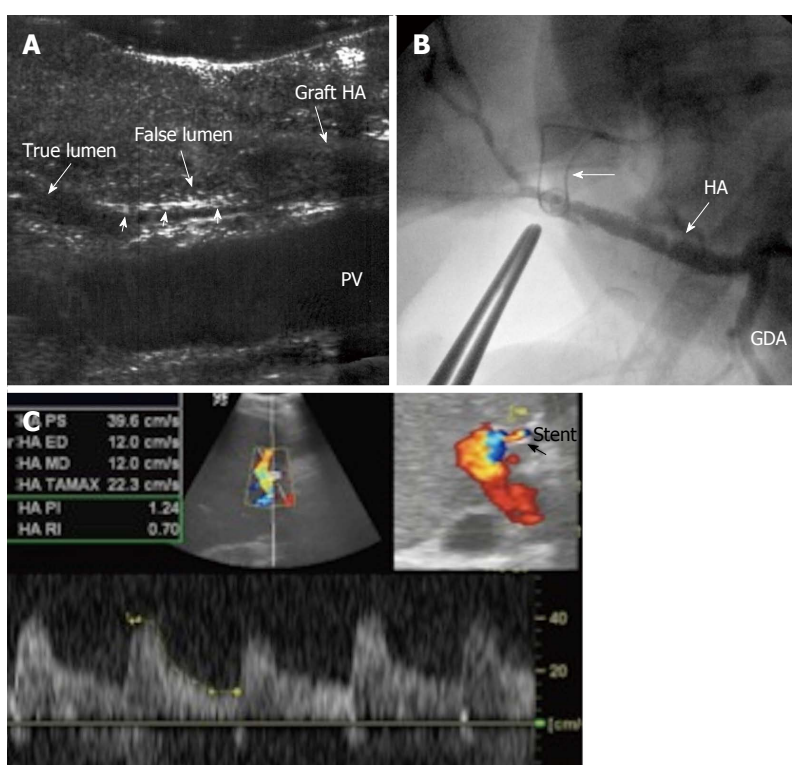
Intra-operative dissection of the graft hepatic artery. A: IOUS B-mode image, showing dissecting intimal flap within the graft artery (arrow heads), the false lumen is seen echogenic and filled with blood and the flap totally occludes the true lumen. Surgical correction failed to repair the dissection; B: Hepatic arteriography image after successful hybrid endovascular stent placement, showing patent HA and good intrahepatic flow. A metallic marker was applied to mark the anastomotic site before stent placement (arrow); C: Doppler US image 4 mo later, confirmed patency of the stent with normal arterial waveform. HA: Hepatic artery.
